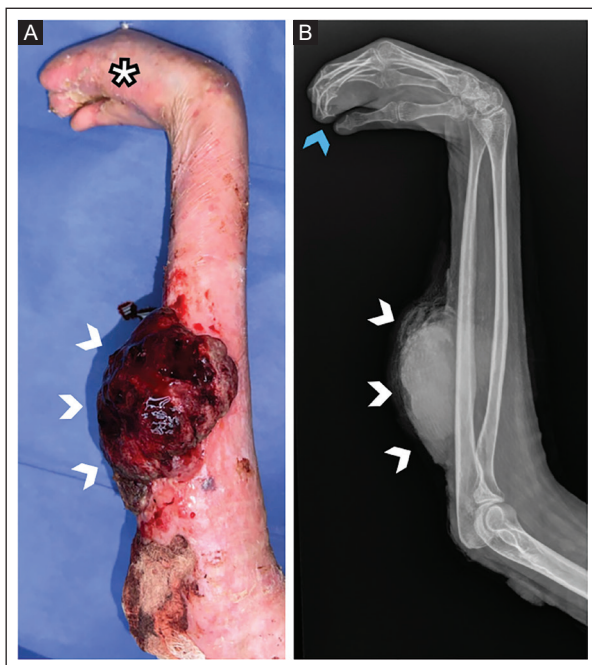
A 27-year-old woman with epidermolysis bullosa and a bleeding exophytic lesion on her left forearm. A: a clinical photograph of the posterior left forearm showing an exophytic lesion with active bleeding (white arrowheads). The hand exhibits a "mitten hand" deformity characteristic of epidermolysis bullosa (asterisk). B: a lateral X-ray of the forearm reveals a large, soft exophytic mass on the left posterior forearm with no bone involvement (white arrowheads). The hand deformity caused by flexion contracture and pseudosyndactyly gives the appearance of a "mitten hand," with hook-like distal phalangeal deformities (blue arrow).
